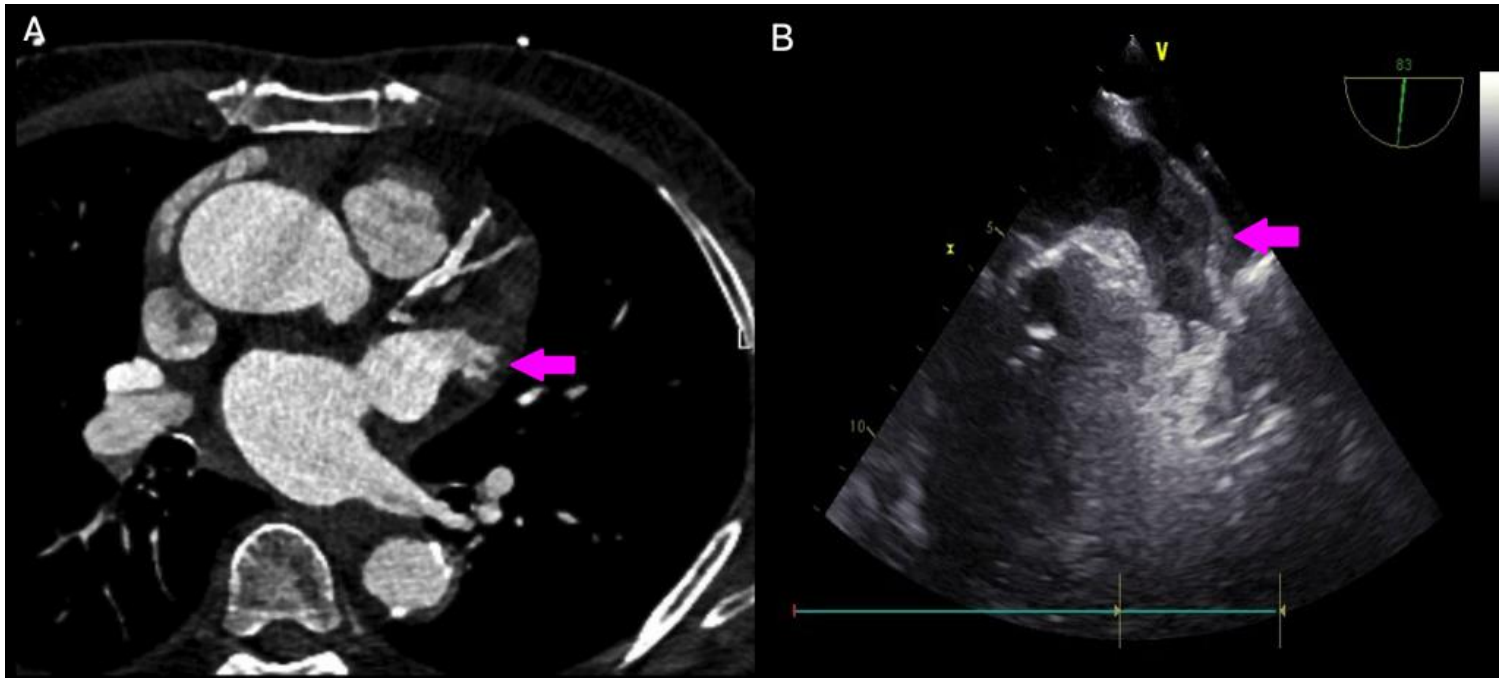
Thrombus in LAA. A; LAA thrombus shown in cardiac CT. B; LAA thrombus shown in TEE. CT; computerized tomography, LAA; left atrial appendage, TEE; transesophageal echocardiography
